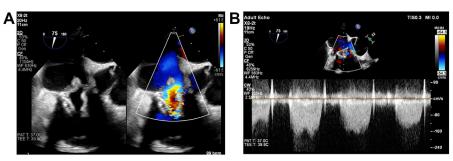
37-year-old with a history of tricuspid valve replacement for infective endocarditis presents with fevers and right-sided heart failure. (*A*) Transesophageal echo with a focus on the bioprosthetic tricuspid valves shows associated echodensities in keeping with vegetations. Color Doppler shows aliasing of flow across the tricuspid bioprosthesis and no significant TR. (*B*) Continuous wave Doppler across the bioprosthetic tricuspid valve shows severe TS with peak and mean gradients of 16 and 10 mm Hg, respectively.
